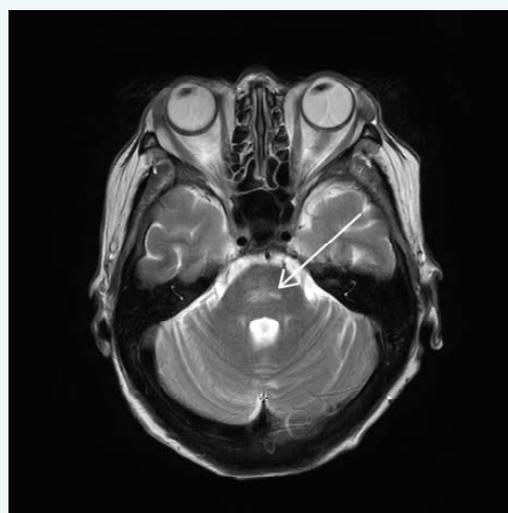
MRI Brain T2 - Hyperintensity lesions in the pons.
